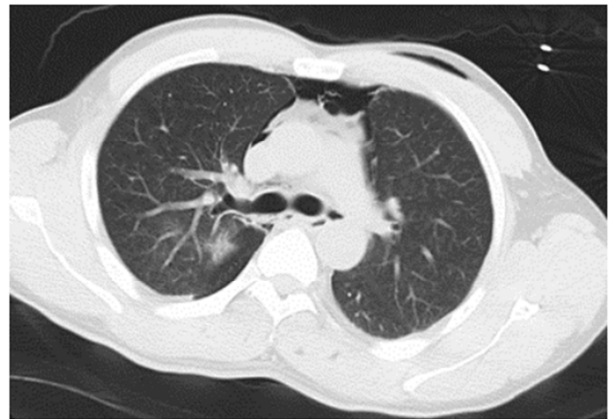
Preoperative chest CT showed multiple gas accumulation in mediastinum and posterior sternum with local lumen stenosis.
